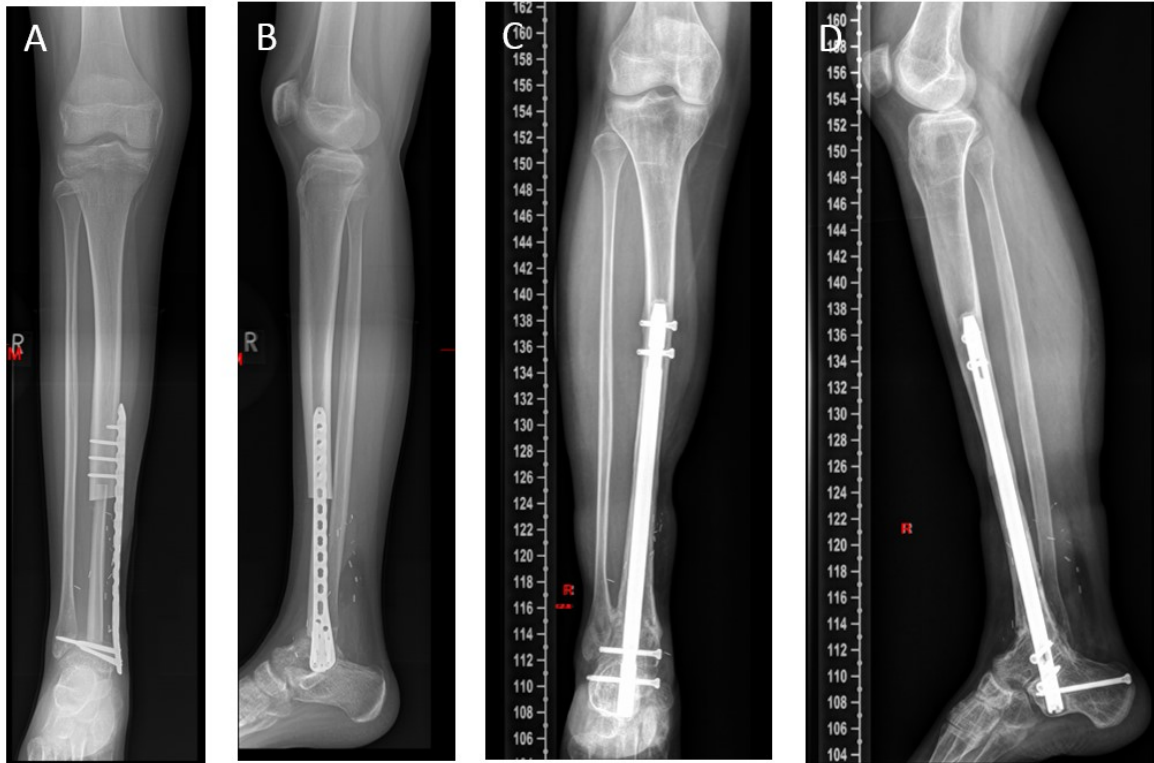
X-Ray of the right lower leg after wide resection of the distal tibia and subsequent reconstruction with vascularized fibular graft and upper ankle joint arthrodesis (A, B). Due to autograft failure and pseudoarthrosis, revision arthrodesis had to be performed after two years (images not shown). X-Ray four years after the initial surgery, showing healed arthrodesis with arthrodesis nail (C, D).
